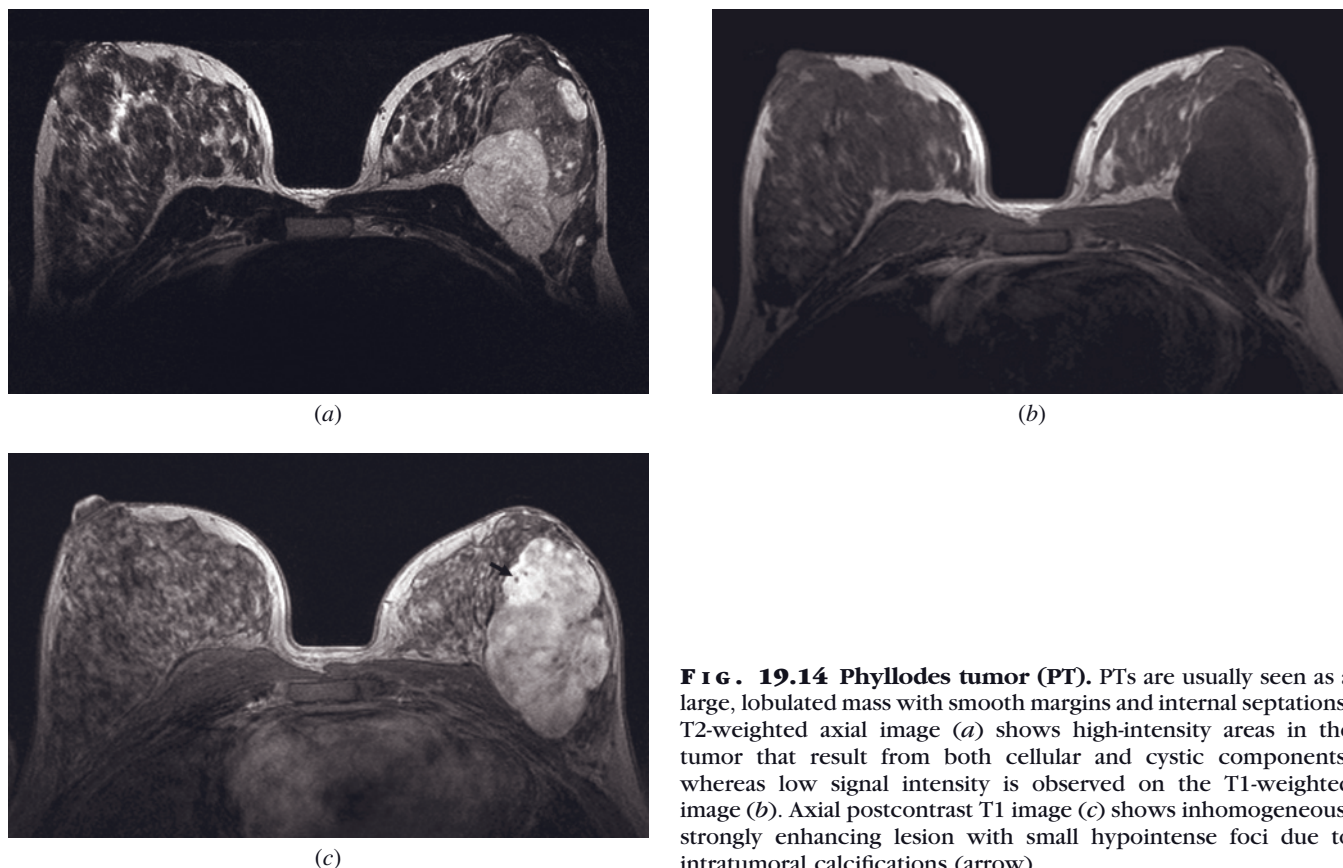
Phyllodes tumor (PT). PTs are usually seen as a large, lobulated mass with smooth margins and internal septations. T2-weighted axial image (a) shows high-intensity areas in the tumor that result from both cellular and cystic components, whereas low signal intensity is observed on the T1-weighted image (b). Axial postcontrast T1 image (c) shows inhomogeneous, strongly enhancing lesion with small hypointense foci due to intratumoral calcifications (arrow).
